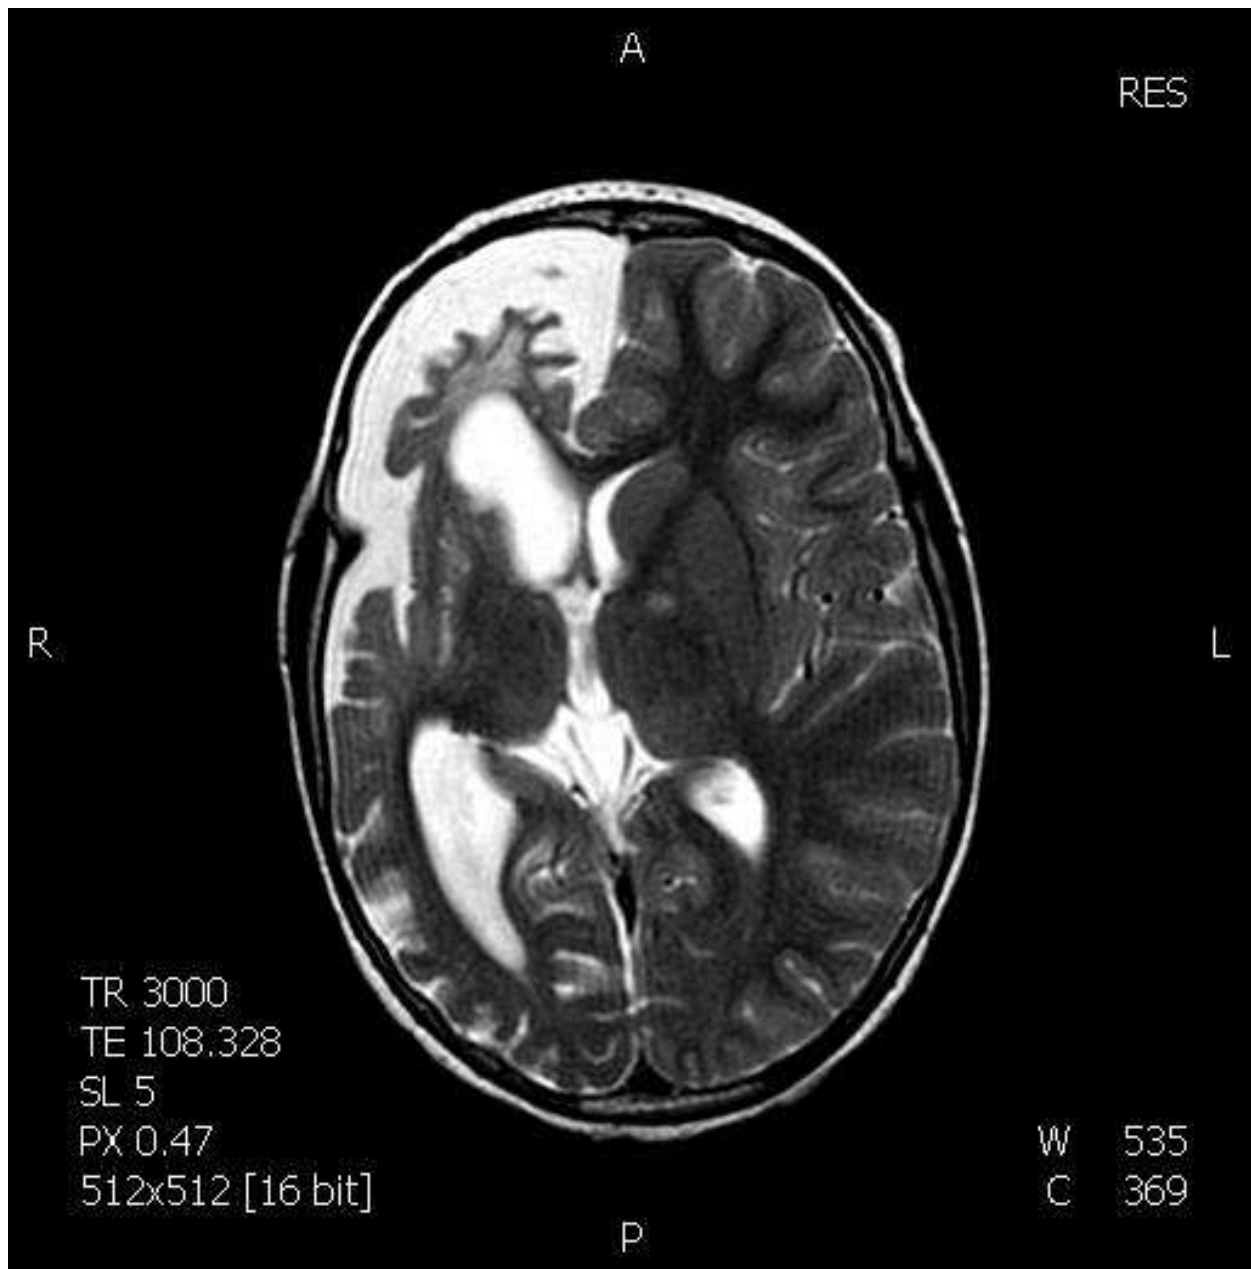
Right cerebral hemisphere atrophy after ischemic lesion: T2-weighted SE image presents a volume loss in the right hemisphere, atrophy of cortical gyri, leukomalacia and ex vacuo enlargement of lateral ventricle. A hyperintense nodule, compatible with spongiotic intramyelinic change (neurofibromatosis), can be appreciated in the left globus pallidus.
